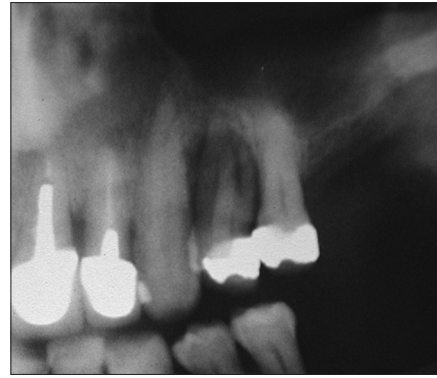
Radiographic exam
